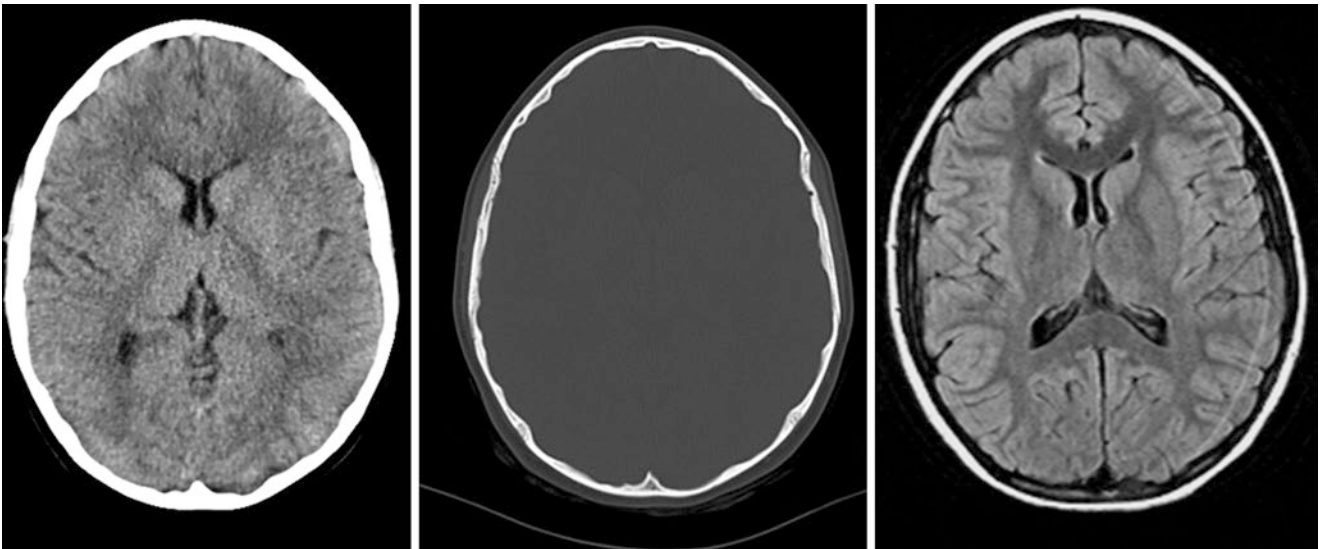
A 12 year old with prominent convoluted markings and a normal-appearing underlying cerebrum on FLAIR MRI (*right*)
